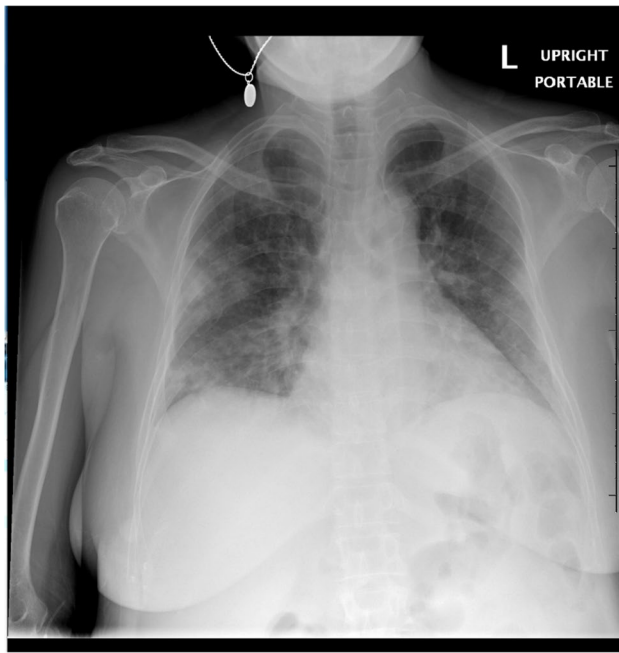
Chest radiography demonstrating bilateral peripheral predominant airspace opacities consistent with SARS-CoV-2 infection
